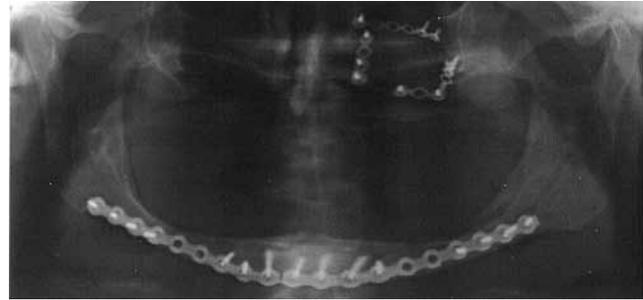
Postoperative x-ray of a double-sided fracture of an atrophic mandible. Fixation with two Mini-Locking-Plates (medium). In addition a left zygoma fracture fixed with three Mini-Locking-Plates (small).
